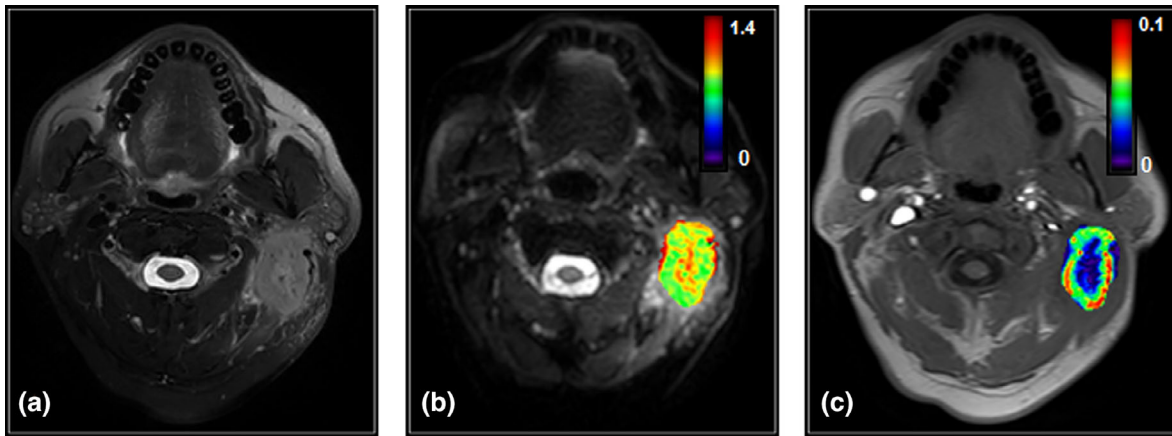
Representative pretreatment MR images of head and neck cancer patient (52 years old, male). (a) T_2 -weighted image, (b) $ADC \times 10^{-3} \text{ (mm}^2/\text{s)}$ map overlaid on diffusion-weighted ($b = 0 \text{ s/mm}^2$) images generated using 10 b -values (0, 20, 50, 80, 200, 300, 500, 800, 1500, and 2000 s/mm^2), (c) $K^{trans} \text{ (min}^{-1}\text{)}$ map overlaid on precontrast T_1 -weighted image. (Images contributed by Amita Shukla-Dave, Memorial Sloan Kettering Cancer Center.)
